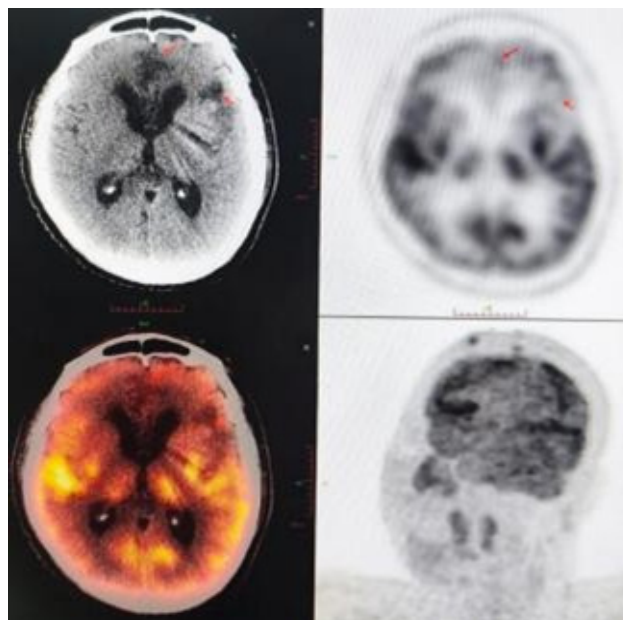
PET-CT showed that after the treatment for diffuse subarachnoid hemorrhage + intraventricular hemorrhage: Changes after coil embolization for the left anterior cerebral aneurysm; Multiple ischemic and degenerative lesions in the bilateral frontal lobes, the left centrum semiovale, the corona radiata and the bilateral periventricular areas, with partial encephalomalacia foci in the left frontal lobe; Symmetrical metabolic reduction in the bilateral frontal lobes, occipital lobes, bilateral basal ganglia and cerebellum, with partial atrophy of the brain parenchyma in the left frontal lobe; The metabolism of partial brain parenchyma in the bilateral parietal lobes and temporal lobes was relatively active; Hydrocephalus, and there was a high possibility of formation of a left porencephalic cyst. Please combine with enhanced CT.
